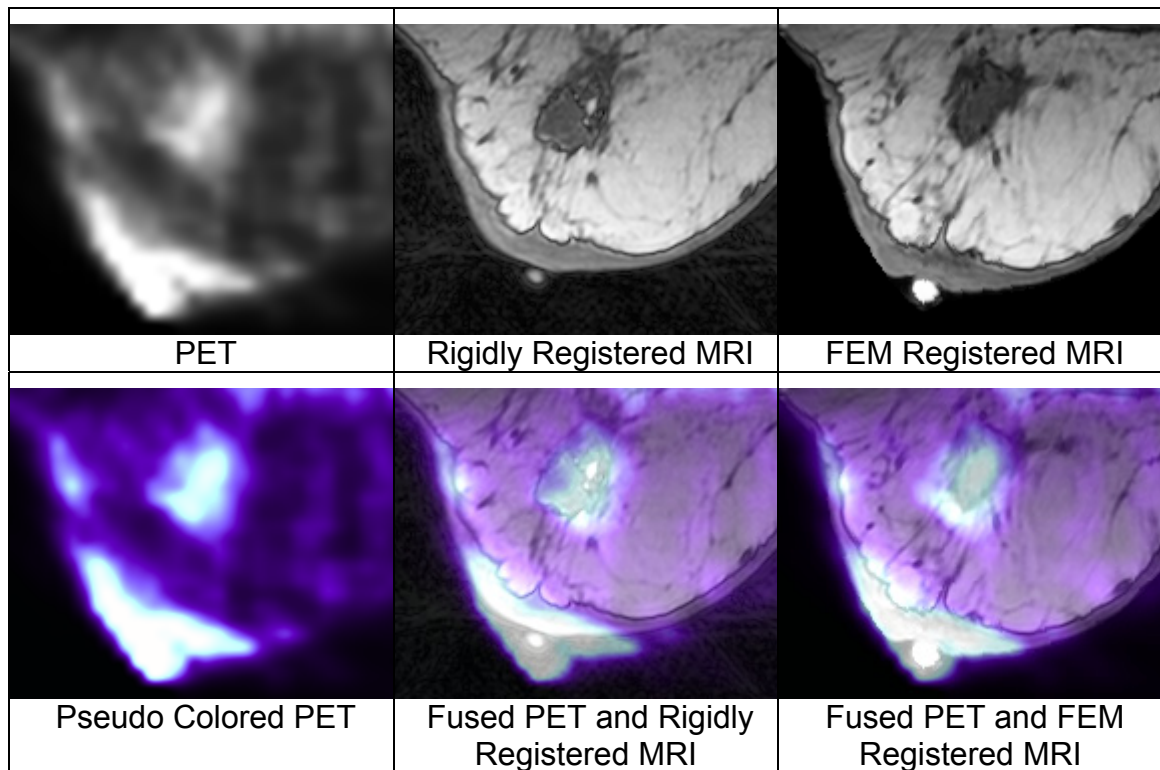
Third example demonstrating the improvement of FEM registration over rigid registration. Original PET image (top left), MRI image after rigid registration (top middle), MRI image after FEM registration (top right), pseudo colored PET image (bottom left), fused pseudo color PET image and MRI image after rigid registration (bottom middle), and fused pseudo color PET image and MRI image after FEM registration (bottom right). Improvements in registration can be seen along the skin surface and at the areas of higher activity within the body of the breast. Look up tables used to pseudo color PET image and fuse MRI and PET images are shown in Figure 2.37 and Figure 2.38, respectively.
